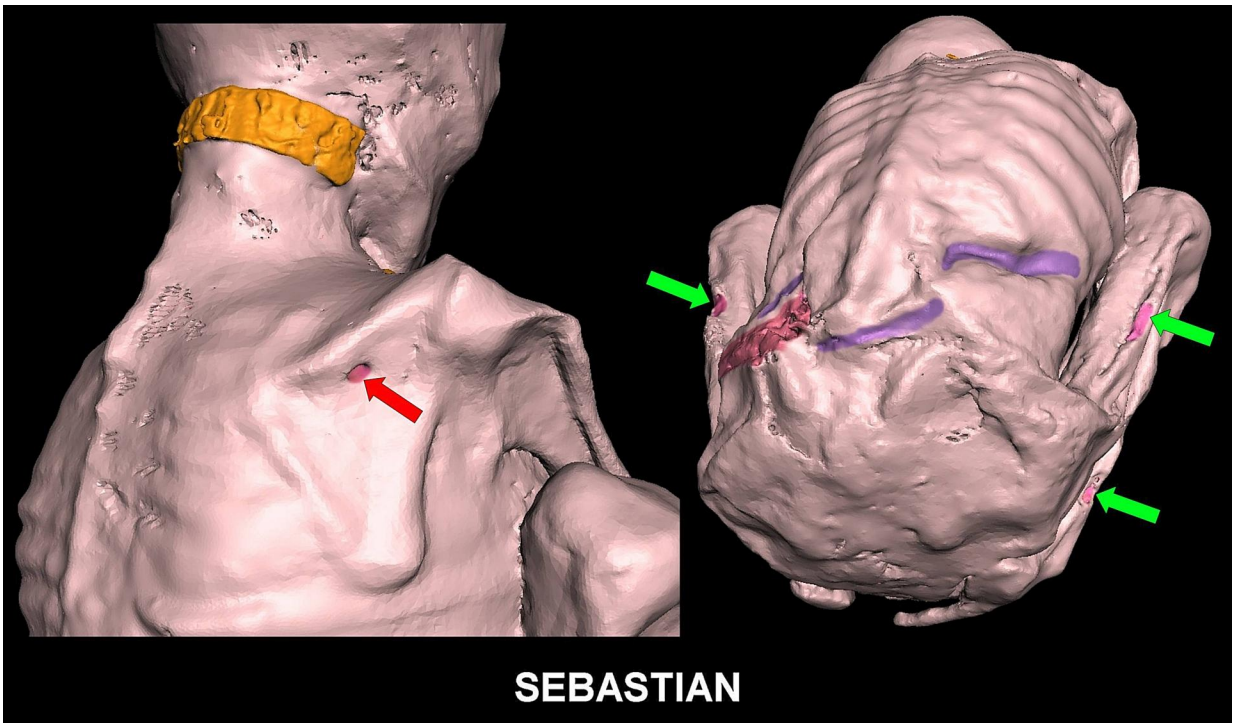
3D CT showing puncture wound (*red arrow*) below right scapular spine (*left*). Areas of tissue loss (*green arrows*) were found in bilateral thighs and right leg (*right*).
